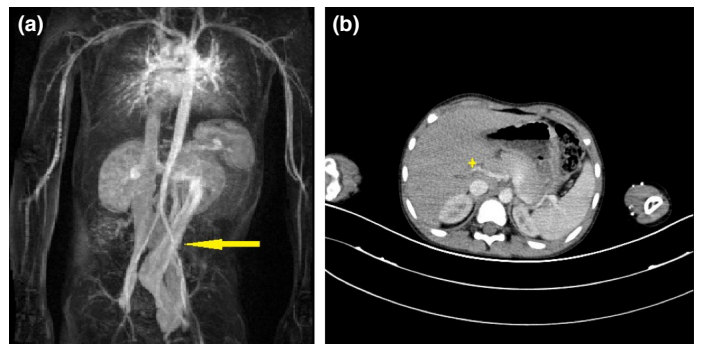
(a) Three-dimensional (3D) phase-contrast MR angiography. A venous, dilated and tortuous vein from the splenic vein was draining to the left iliac vein, extending toward the left iliac fossa. Inferior vena cava, left renal vein and SMA were dilated secondary to the increase in flow (yellow arrow). (b) Portal vein is invisible on triphasic CT of abdomen with iv contrast (yellow star).
